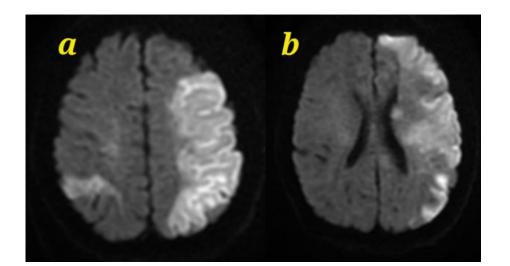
Diffusion weighted MRI images
